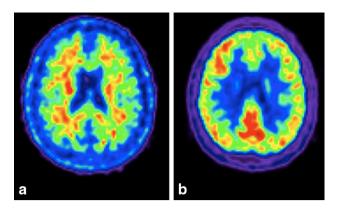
Example case of cognitively intact subject (58 years old, education: 8 years) with negative amyloid PET (a) and negative FDG PET (b). a amyloid PET shows no tracer uptake in cortical gray matter, but only aspecific uptake in white matter. b FDG PET scans shows normal brain metabolic activity, particularly in temporoparietal regions
